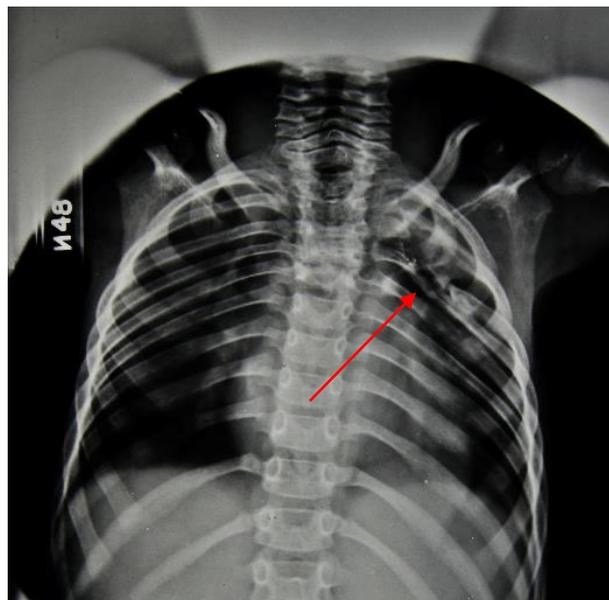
Radiograph showing resection of left ribs three & four, 1945. The arrow indicates the portion of rib shaft removed (HOSP/STAN/7/1/2/1163_02)
